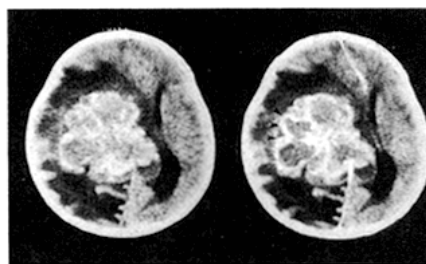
X-CT, axial plain. *Left*, plain. A huge multilobular tumor with a high-density rim surrounded by a broad low-density area was seen in the right hemisphere. *Right*, enhanced. An enhancement effect was also noted in the rim (*arrowheads*).
